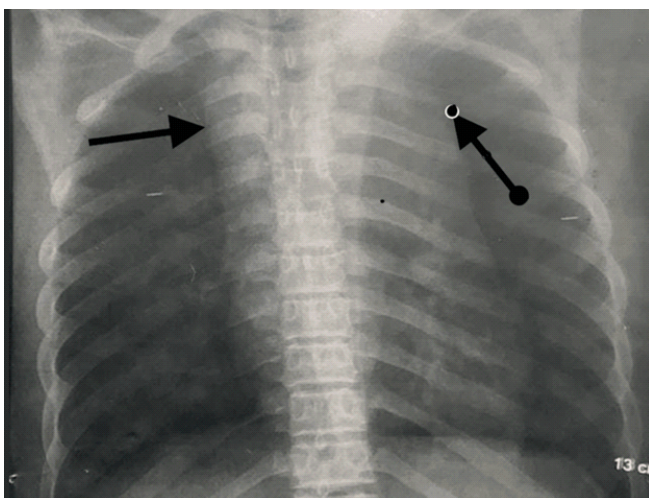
Chest X-ray showing a widened mediastinum. The transverse width of the mediastinal silhouette is markedly increased . No evidence of pneumothorax or hemothorax is seen.
